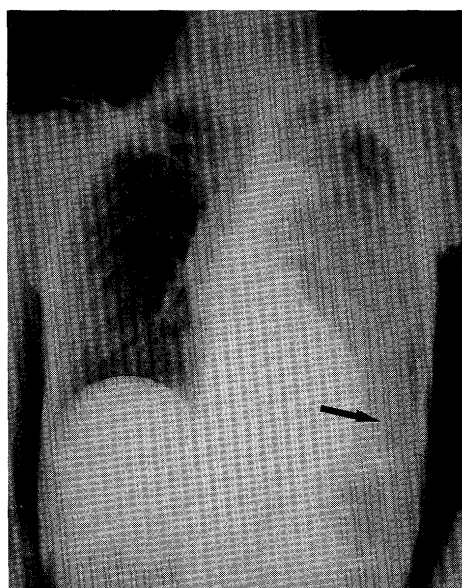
(B) Radiograph of the chest demonstrating migration of the catheter (arrow head) into the thorax. The left cerebrospinal fluid hydrothorax is revealed
